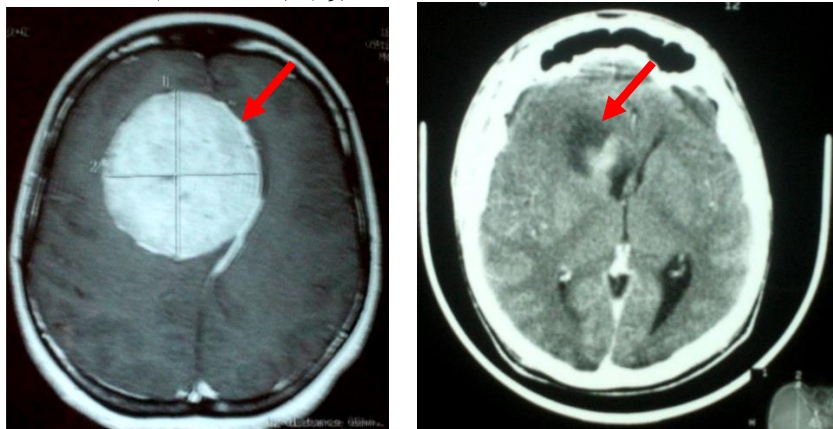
MRI: gigantic olfactory groove meningioma, pre- and post-operative
